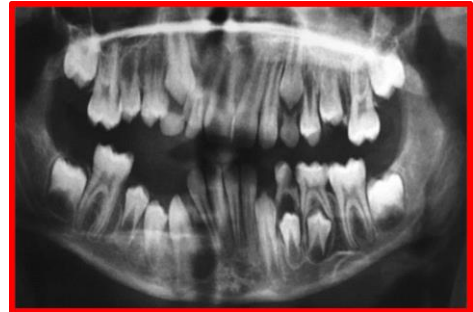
Panoramic radiograph taken at 1 year follow up showing premolars erupting into position and bone cavity healed completely
